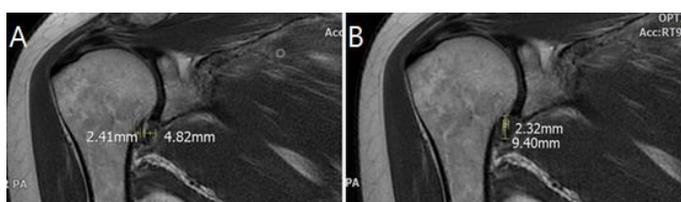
Coronal T2 fat-suppressed MRI sequence A: thickness of inferior glenohumeral ligament in mid-axillary recess (glenoid and humeral side) B: measuring of height and width of axillary recess
